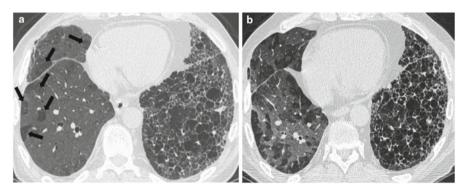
HRCT imaging of BOS. (a) shows multiple areas of air-trapping (arrows) in the lung allograft of the recipient of a right single-lung transplant for pulmonary fibrosis; (b) shows progression of air-trapping due to progressive obliterative bronchiolitis on repeat HRCT obtained 1 year later
